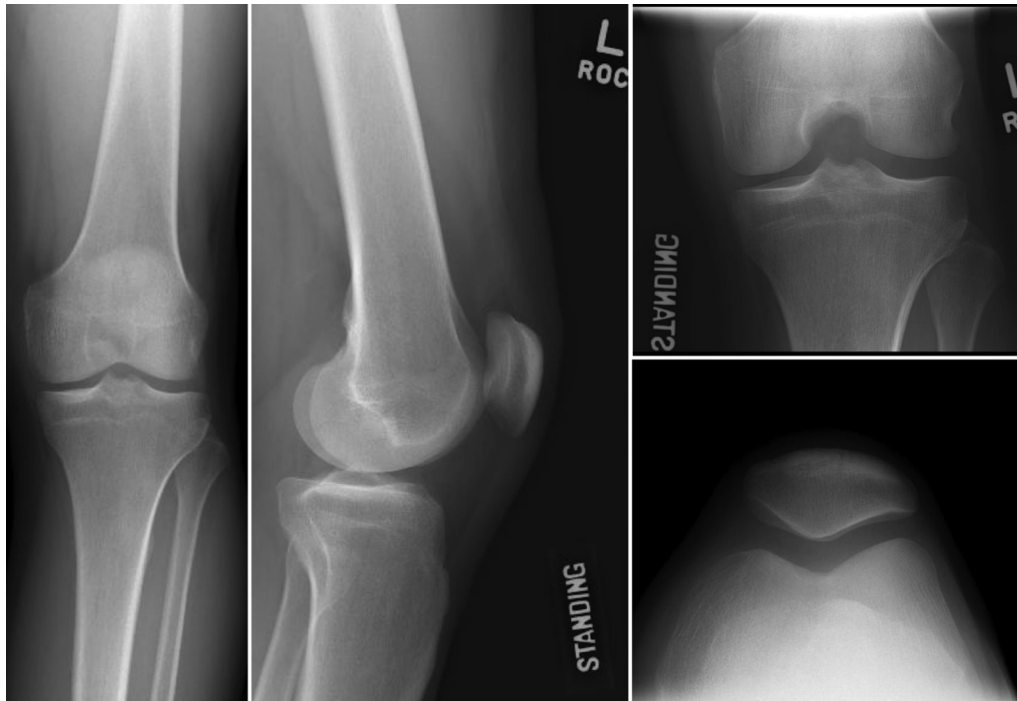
Sixty-six-year-old male with 18 months of left knee pain. Knee radiographs revealed Grade 0 OA.
